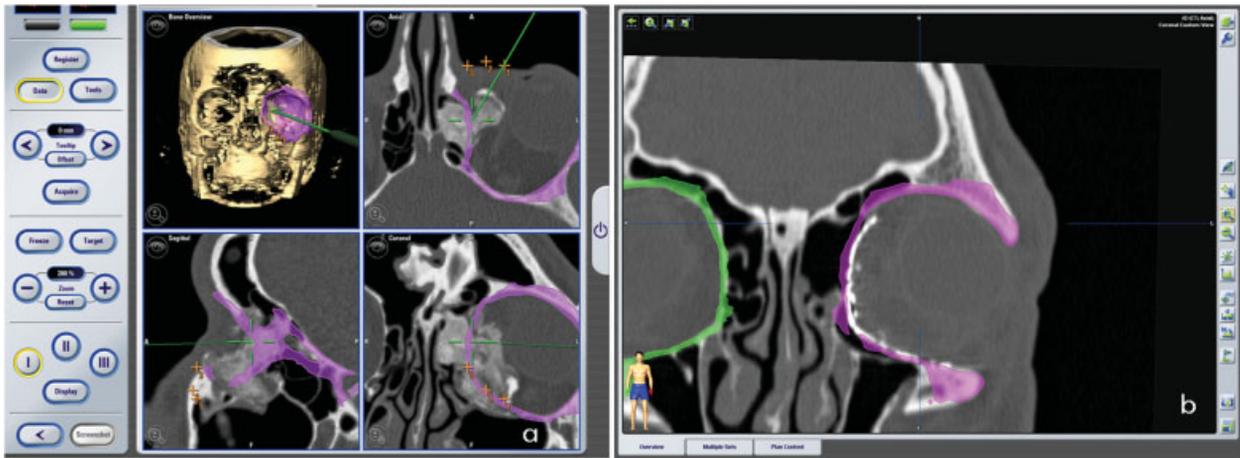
(a) Real-time navigation imaging; (b) postoperative CT scan superimposition on preoperative planning.
